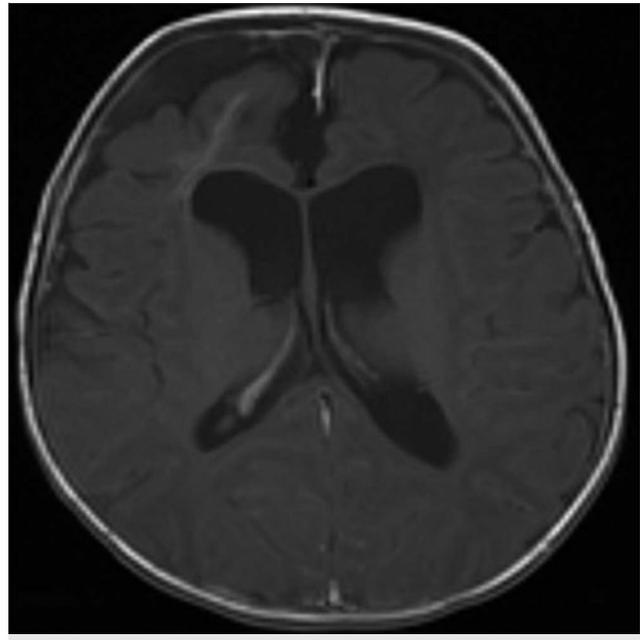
Axial T1-weighted magnetic resonance imaging sequence with gadolinium administration showing evidence of residual contrast enhancement nearly 6 weeks following evacuation of a right frontal brain abscess.
